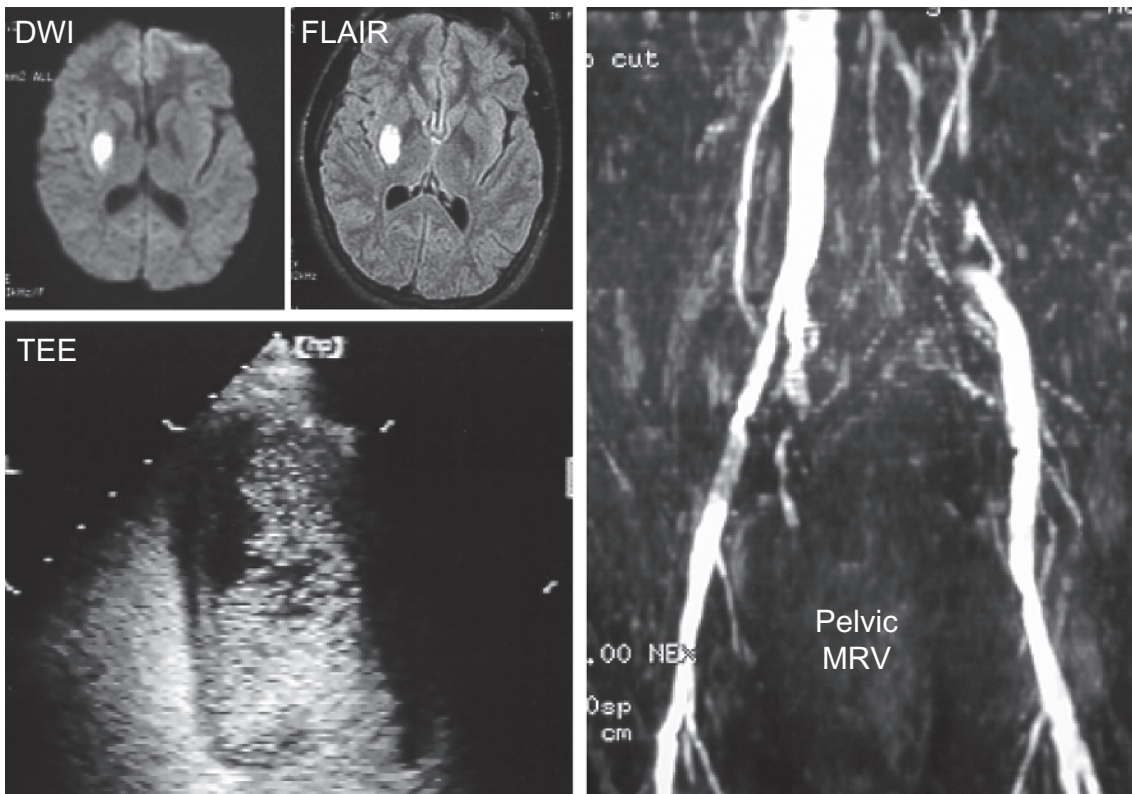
MRI findings in a young patient with paradoxical embolism and patent foramen ovale on transesophageal echocardiography (TEE). DWI and fluid-attenuated inversion recovery (FLAIR) show a subacute lesion despite complete symptom resolution at the time of MRI. MR venogram of the pelvis (right) shows flow void due to thrombus. TEE shows air bubble passage into the left ventricle after intravenous injection of agitated saline.
